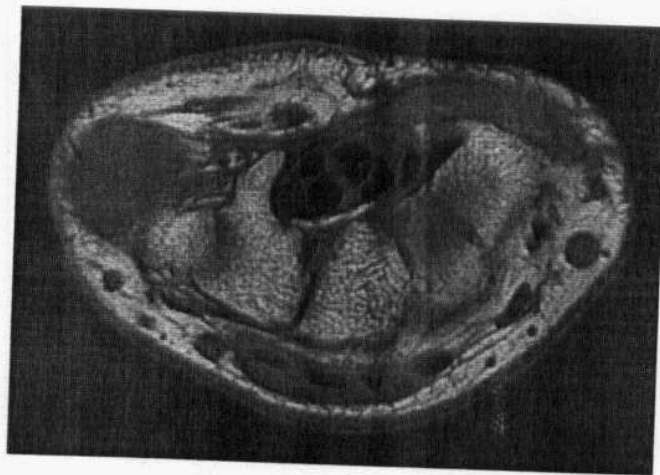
T2-weighted axial MRI at the level of the carpal bones show tubercle of trapezium, trapezoid, capitate, hook of hamate, flexor retinaculum, median nerve, carpal tunnel, (Quoted from Nadja Saupe, et al.,2005).
